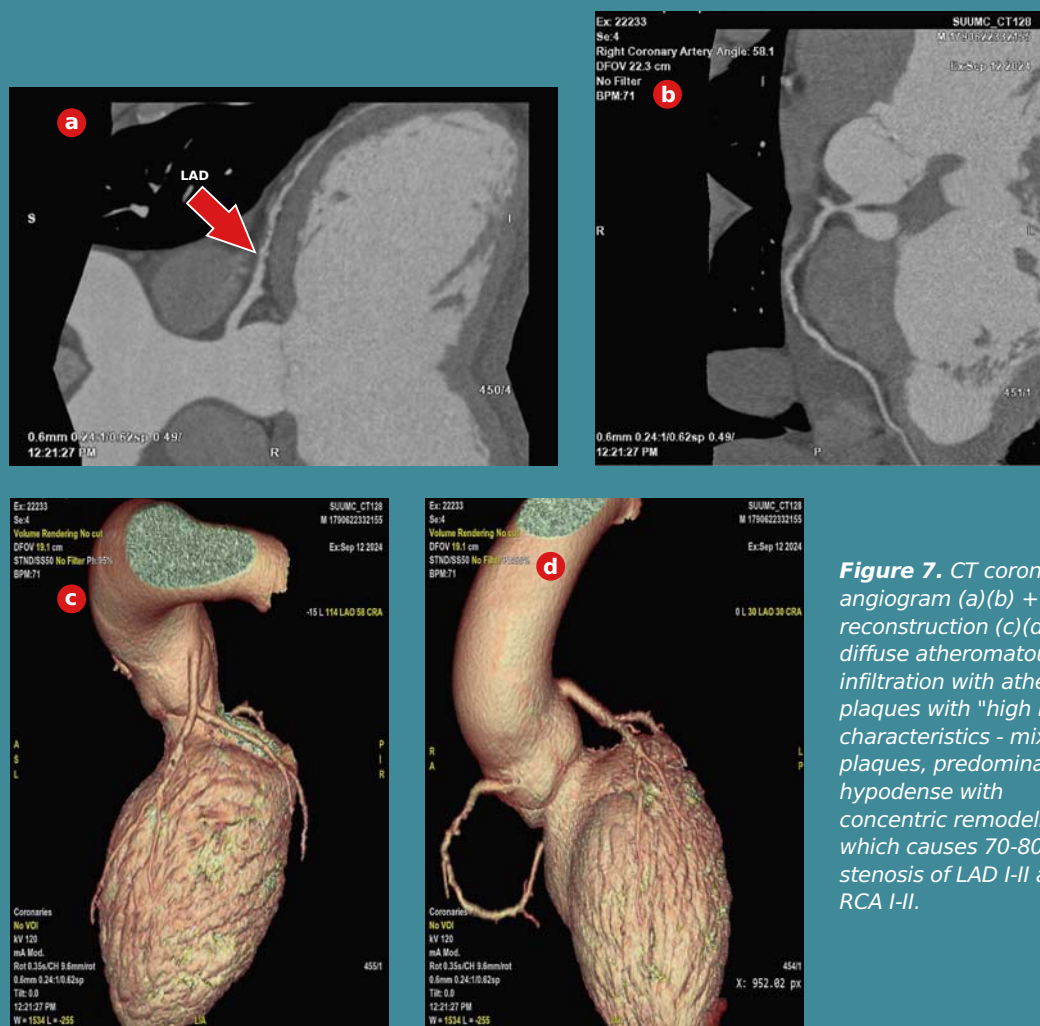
CT coronary angiogram (a)(b) + 3D reconstruction (c)(d)-diffuse atheromatous infiltration with atheroma plaques with "high risk" characteristics - mixed plaques, predominantly hypodense with concentric remodeling which causes 70-80% stenosis of LAD I-II and RCA I-II.
